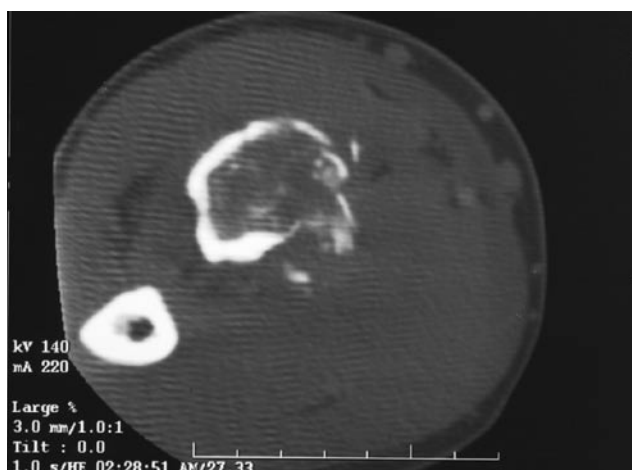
Computed tomography scan of lesion with intralesional calcification. Cortical disruption is apparent.
